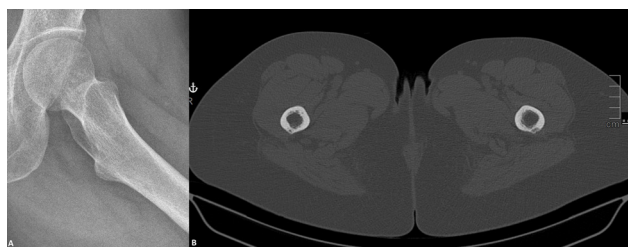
Lateral left hip radiograph (A) and axial non-enhanced CT image in bone window (B) are unremarkable. Both were obtained three months after symptom onset.
